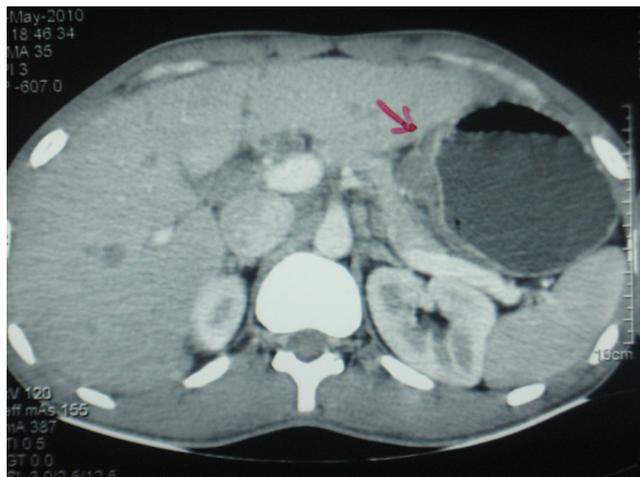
CT abdomen showing thickened gastric wall along lesser curvature.
